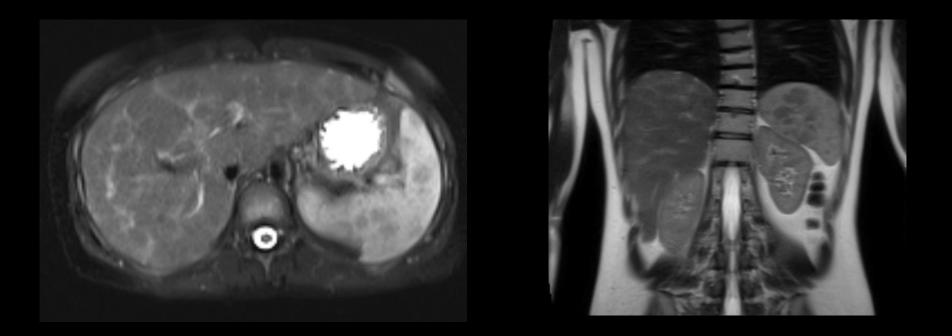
MRI, T2-wheighted images. Focal spleen hypointense lesions.
